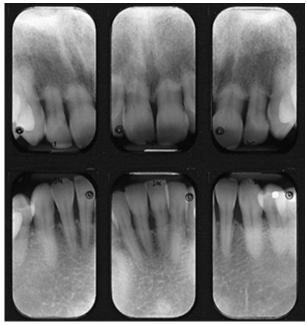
Anterior periapical radiographs of multiple teeth with external resorption, particularly severe on the maxilla.
